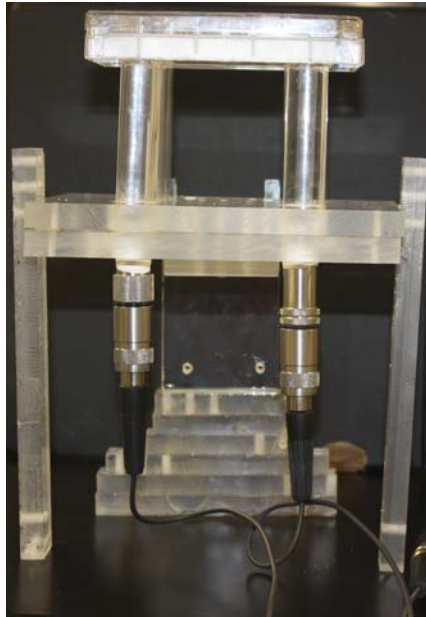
The real assembly of the custom LIPUS system composed of both focused and plane wave transducers, acrylic column for ultrasound wave transmission, and 12-well plate for cell seeding. The transducers were connected to and excited by a multi-channel tone burst pulser/receiver where the different parameters (PRF, duty cycle etc.) of input signals can be adjusted.
